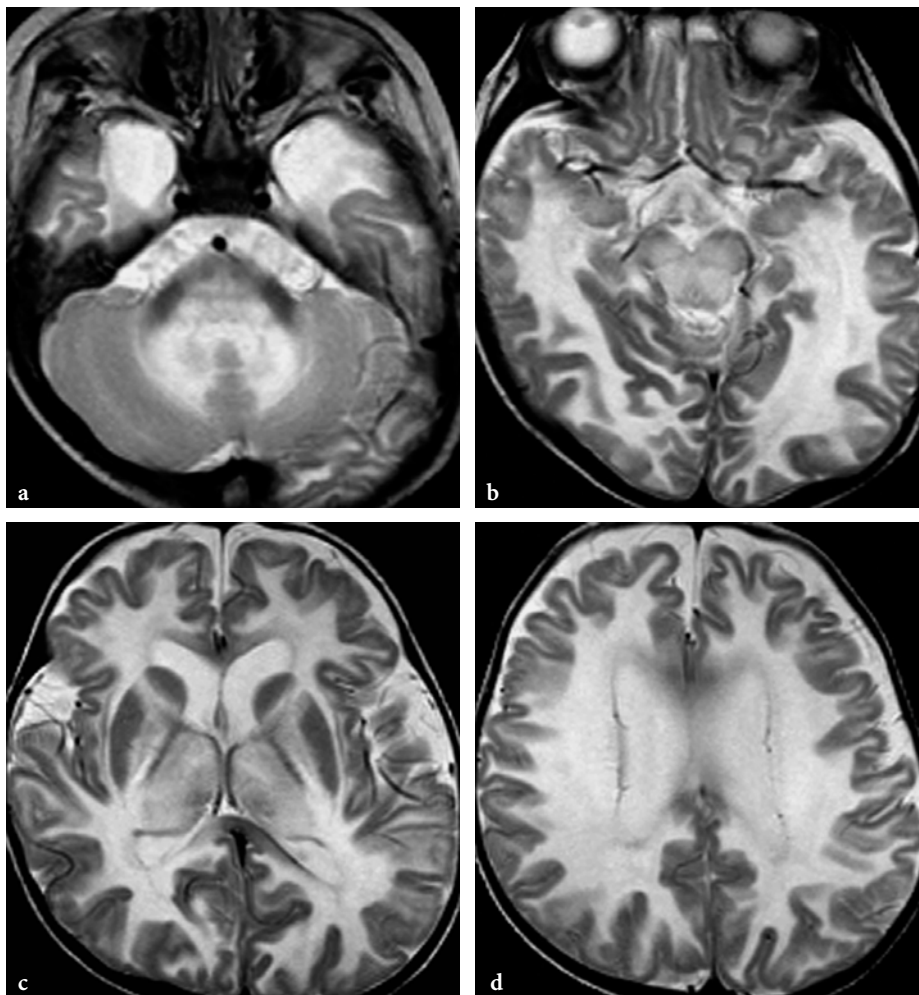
Conventional MR imaging findings in a 1-year-old male patient with Canavan disease. a–d Axial T2-weighted fast spin-echo images. The white matter disease is already quite extensive, but in a few areas myelin is relatively spared. These include the ventral brainstem structures, lateral aspects of middle cerebellar peduncles, internal capsules, and corpus callosum. The latter suggest a centripetal progression pattern. Note involvement of the thalami and globi pallidi
